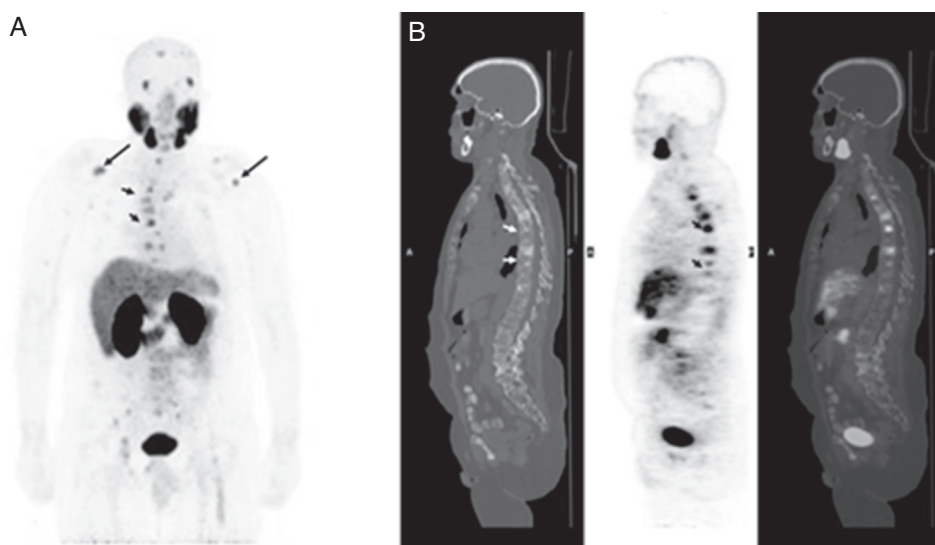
Post-therapy ^{68}Ga -PSMA PET/CT showed decreased radiotracer uptake in supraclavicular lymph nodes and bones metastases but there were new uptake sites in both humeri (arrows) and vertebral bodies (arrow heads) in PET (MIP) (A) and (B) sagittal CT, PET and fusion images, respectively.
